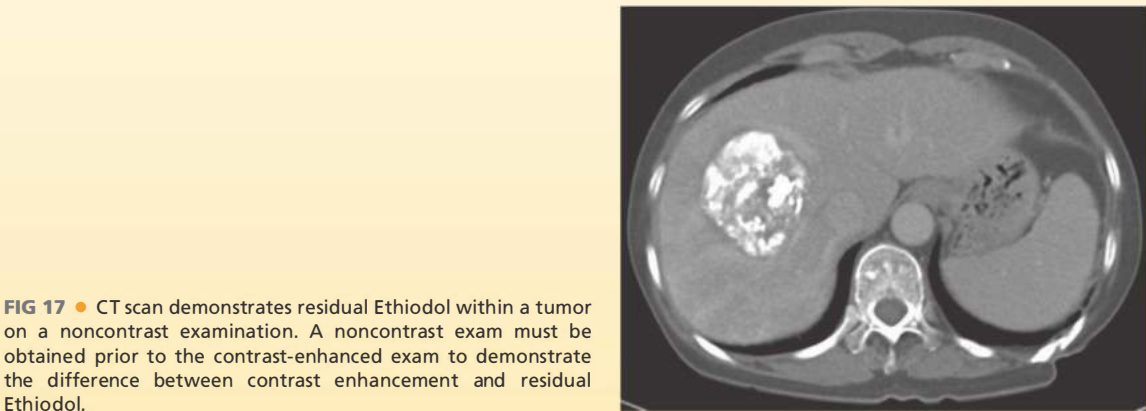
• CT scan demonstrates residual Ethiodol within a tumor on a noncontrast examination. A noncontrast exam must be obtained prior to the contrast-enhanced exam to demonstrate the difference between contrast enhancement and residual Ethiodol.
